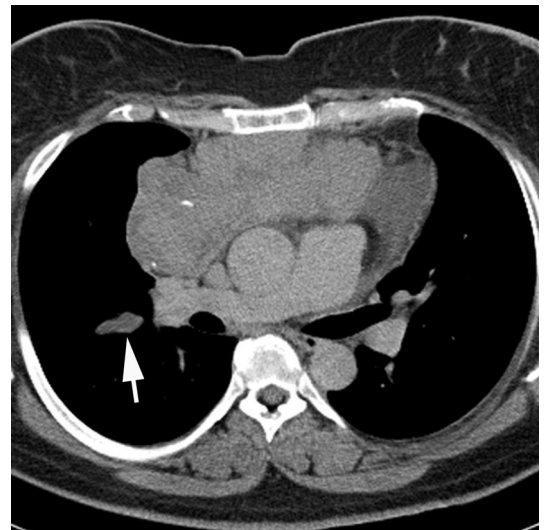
Invasive thymoma. Contrast-enhanced axial CT shows a large, lobulated, heterogeneously enhancing, prevascular mediastinal mass with intrinsic calcification and absence of a tissue plane between it and the pericardium, concerning for invasion. Note right pleural metastasis along the major fissure (arrow).
